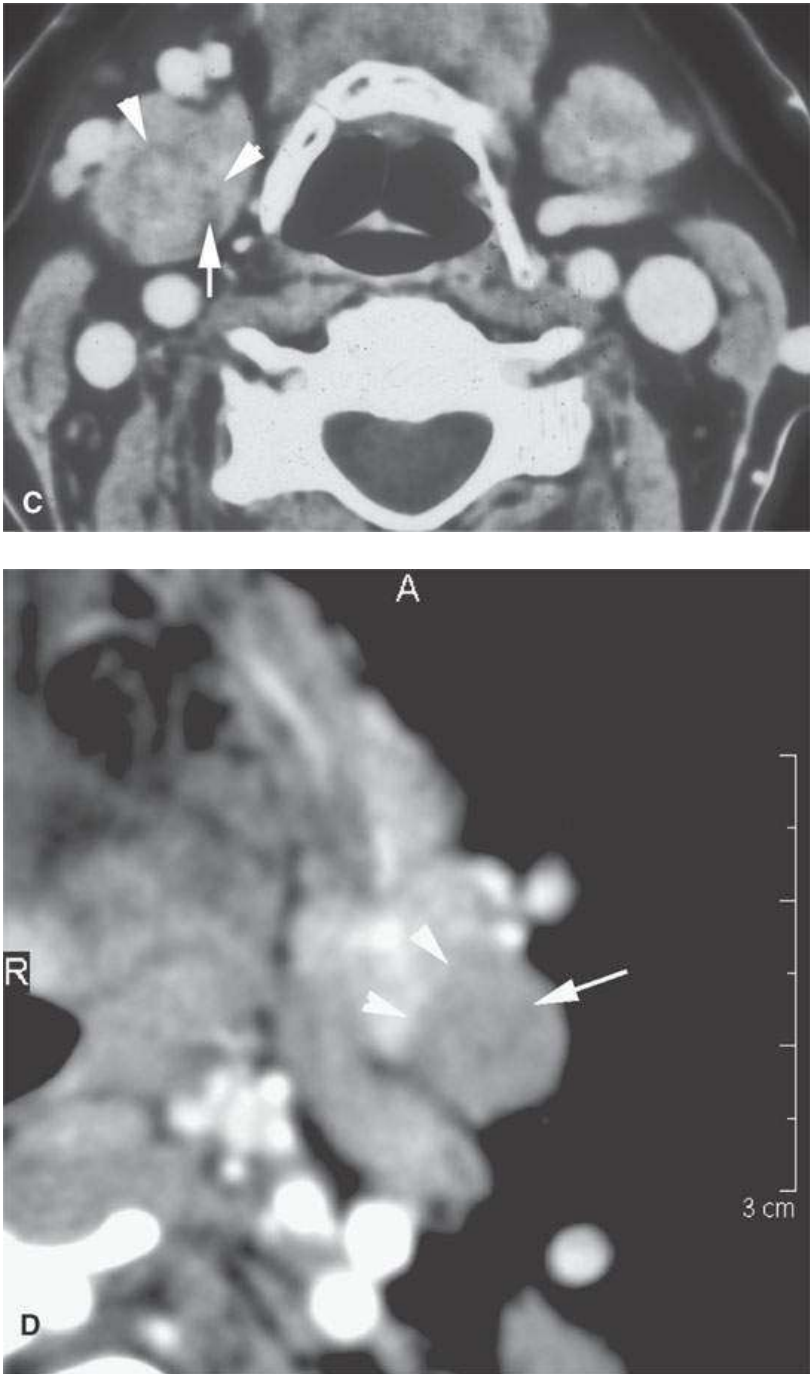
A–D: Contrast-enhanced computed tomography of four benign mixed tumors of the submandibular: one that is relatively low density (A), one that is minimally enhancing (arrowheads in B), one that is sharply margined (arrowheads in C) and but for its peripheral lucency would be difficult to tell from the rest of the gland parenchyma (arrow), and one that does not enhance but is sharply margined (arrowheads in D); the gland does enhance, and tumor protrudes from the gland surface (arrow).
